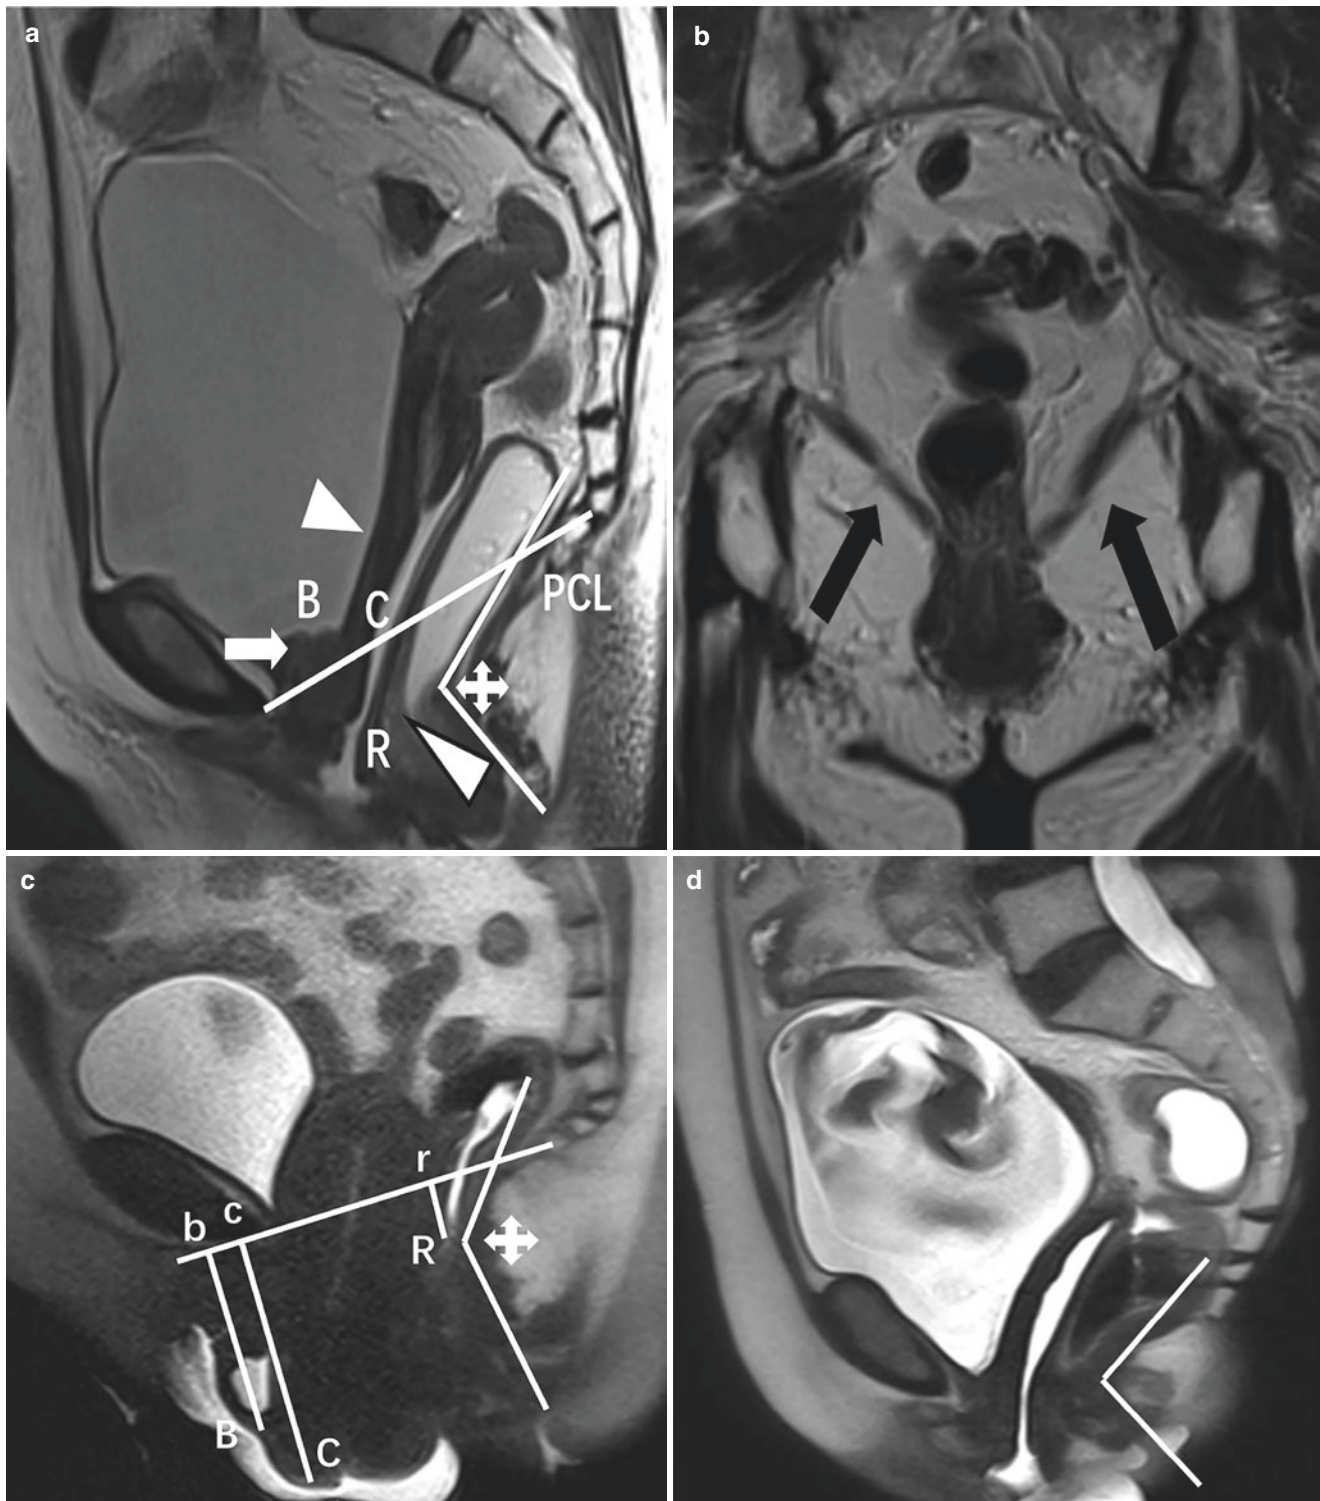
Multiplanar MRI images of a female patient with pelvic organ prolapse (POP). (a) Midline sagittal section of a female patient at rest, this section should encompass the pubic symphysis, bladder neck, vagina, rectum, and coccyx. “PCL” line is the line from the lower border of the pubic symphysis to the last coccygeal joint, representing the level of the entire pelvic floor. Letter “B” in figures represents the lowest point of bladder neck (white arrow); letter “C” in figures represents the most inferior and anterior point of the cervix (white arrowhead); letter “R” in figures stands for ano-rectal junction (black framed arrowhead). The ano-rectal angle is within the normal range (asterisk). (b) Coronal T2WI
